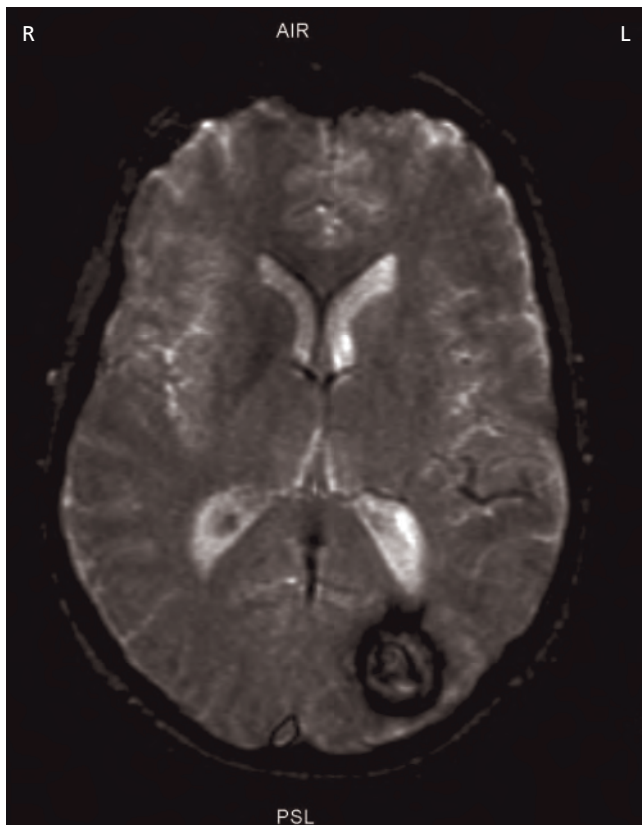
Occipital cavernoma (MRI T2*).
